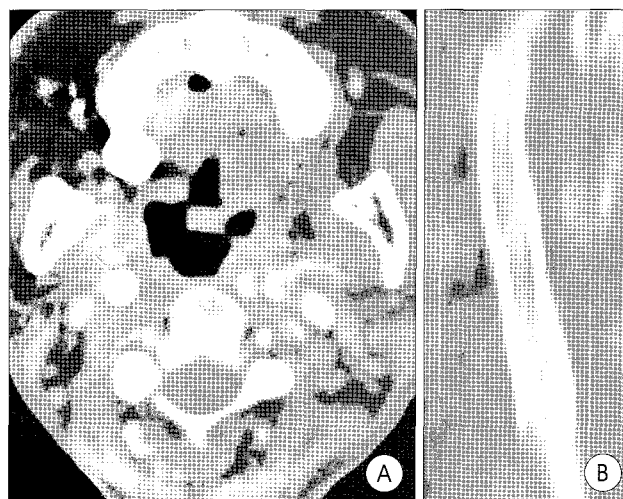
48 months after carotid stenting, the follow-up CT study reveal a good flow through the stented segments. A : Axial view. B : Lateral view.
